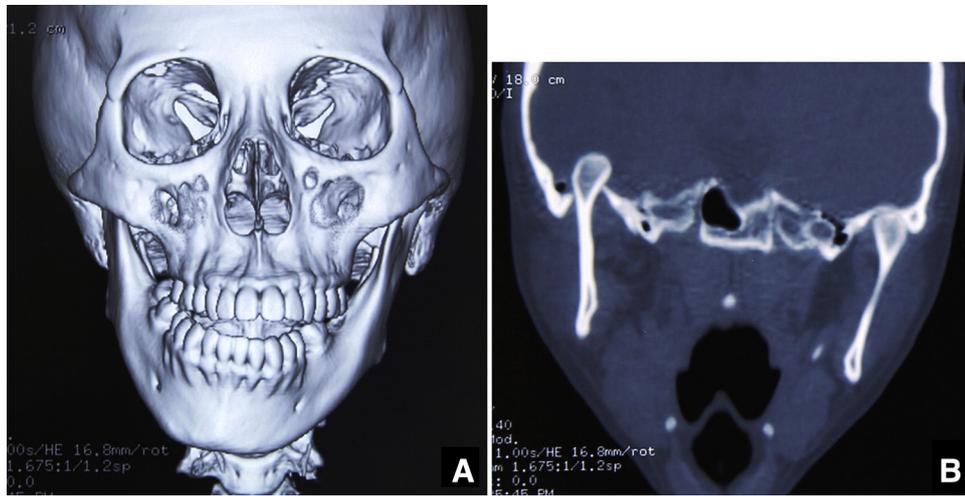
Preoperative CT images of case 2. (A) Three-dimensional reconstruction CT scan. (B) Coronal CT scan: the condyle is displaced superiorly, deep into the skull.
